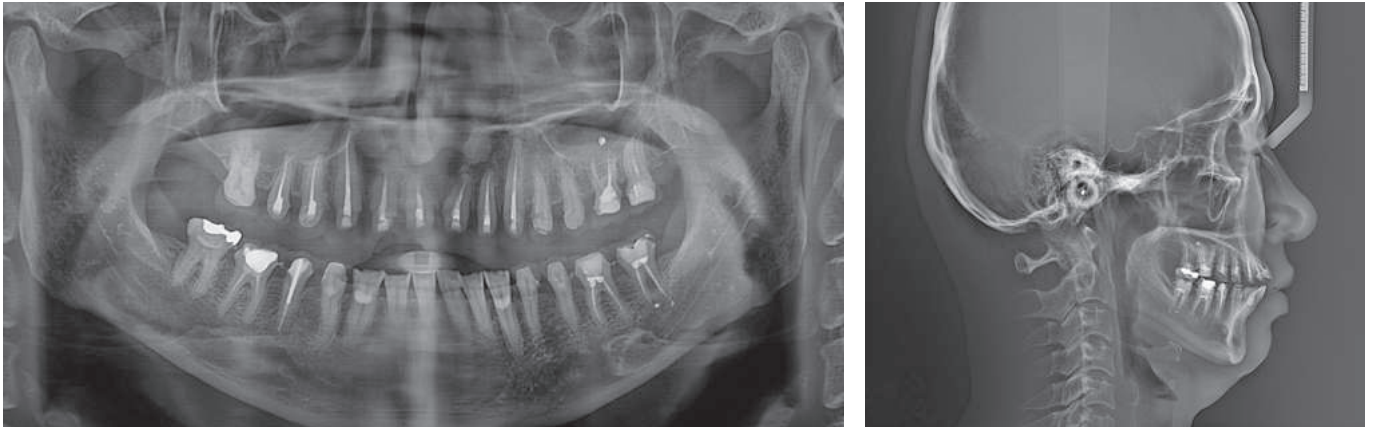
Panoramic radiographs and cephalometric radiographs with provisional restorations in place
